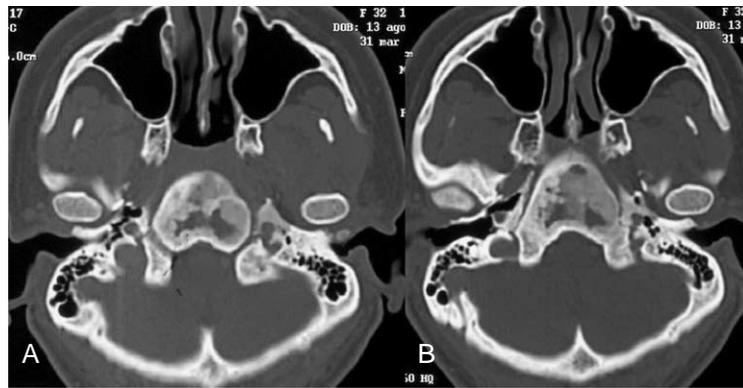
Axial CT scans showing ground-glass appearance and cystic lesion of the clivus (A) with left condylar involvement (B).
